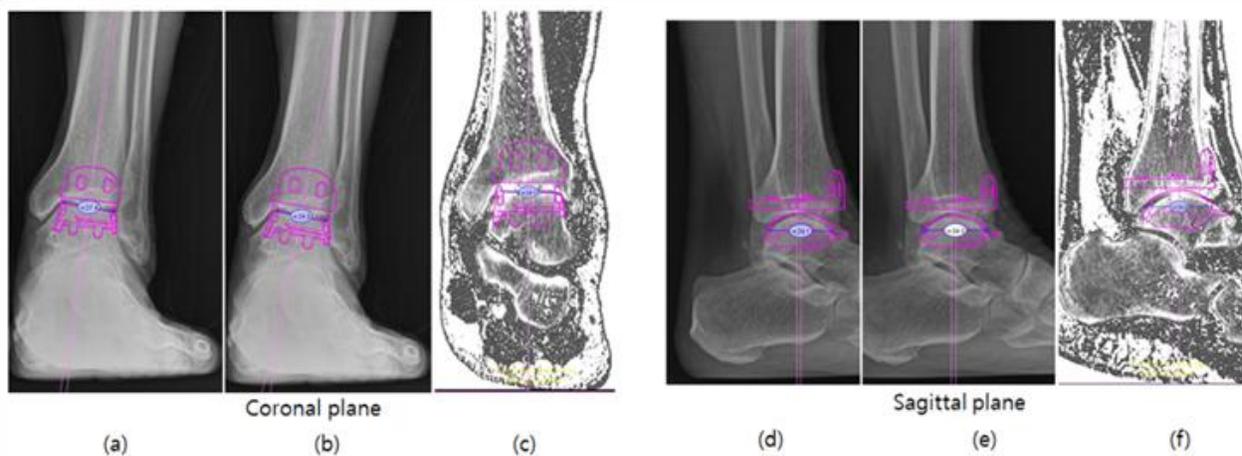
Comparison of the different templating sizes in the TAR components measured by using Orthoview™ software based on x-ray and CT images on the coronal plane (a) 100% magnification x-ray image; (b) 115% magnification x-ray image; (c) CT image and the sagittal plane (d) 100% magnification x-ray image; (e) 115% magnification x-ray image; (f) CT image.
